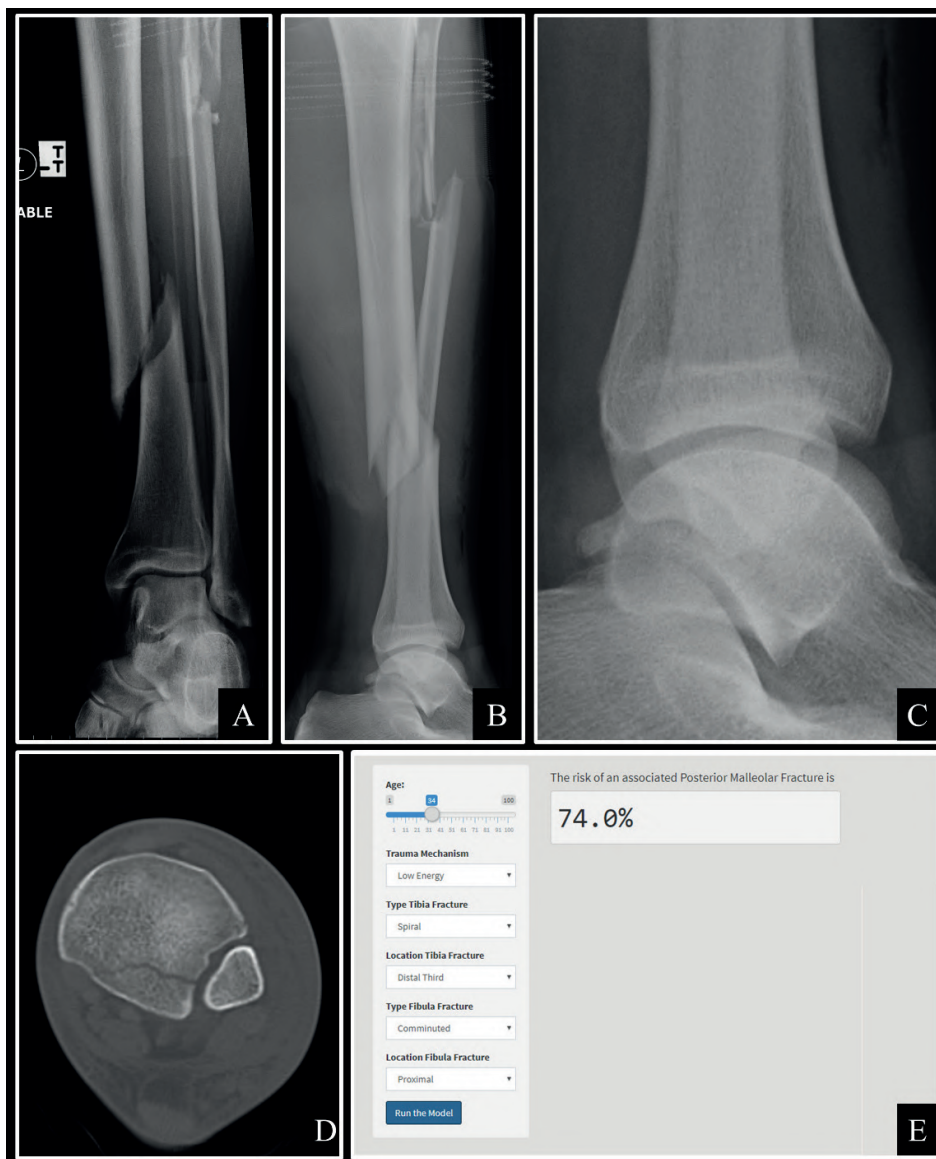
A 34-year old male with a spiral, distal third tibia shaft fracture and a comminuted, proximal third fibula fracture after a low-energy trauma. Pre-operatively there was no posterior malleolar fracture identified on lateral plain radiographs (A-C), but postoperative CT-scan imaging demonstrated a posterior malleolar fracture. (D). When the patient specific characteristics of this case were retrospectively fed into the prediction tool it generated an 74% probability of a posterior malleolar fracture (E).
